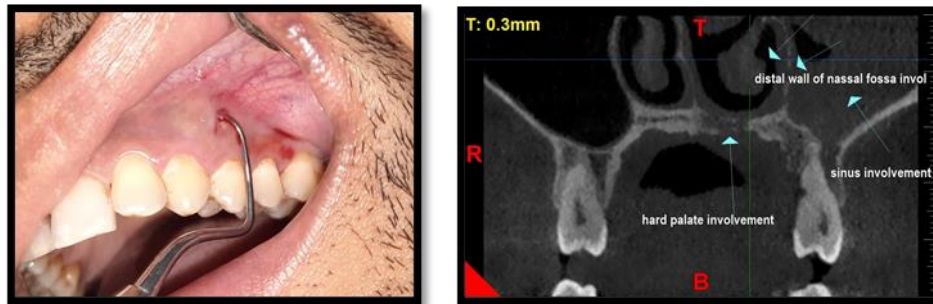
Initial clinical presentation of Mucormycosis with single periodontal abscess being curretted; 1b) CBCT revealing hard palate, distal wall of nasal fossa and sinus involvement.
